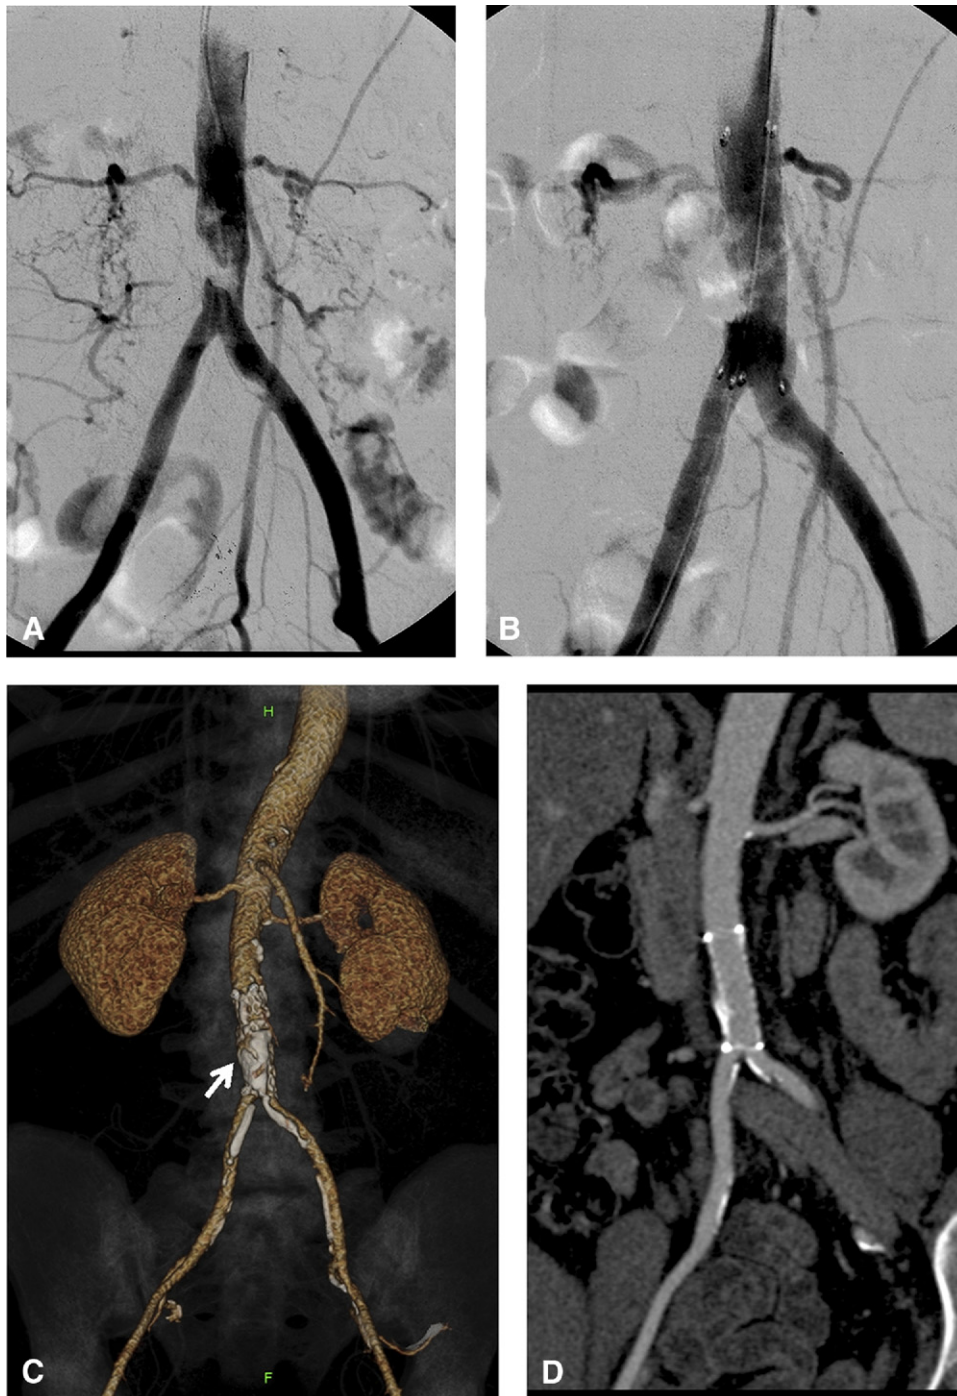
Angiography of a 70-year-old woman with focal aortic stenosis at the distal part of the aorta. A and B, Through a right femoral retrograde approach it was possible to cross and stent the lesion with a single self-expandable stent (Luminex, C.A. Bard). C and D, Computed tomography (CT) scan 2 years later shows the stent integrity and the calcified aortic plaque (3D volume rendering modality, *white arrow*). On the left, a curved planar reformation passing through the aortic lumen shows the absence of a restenosis.
